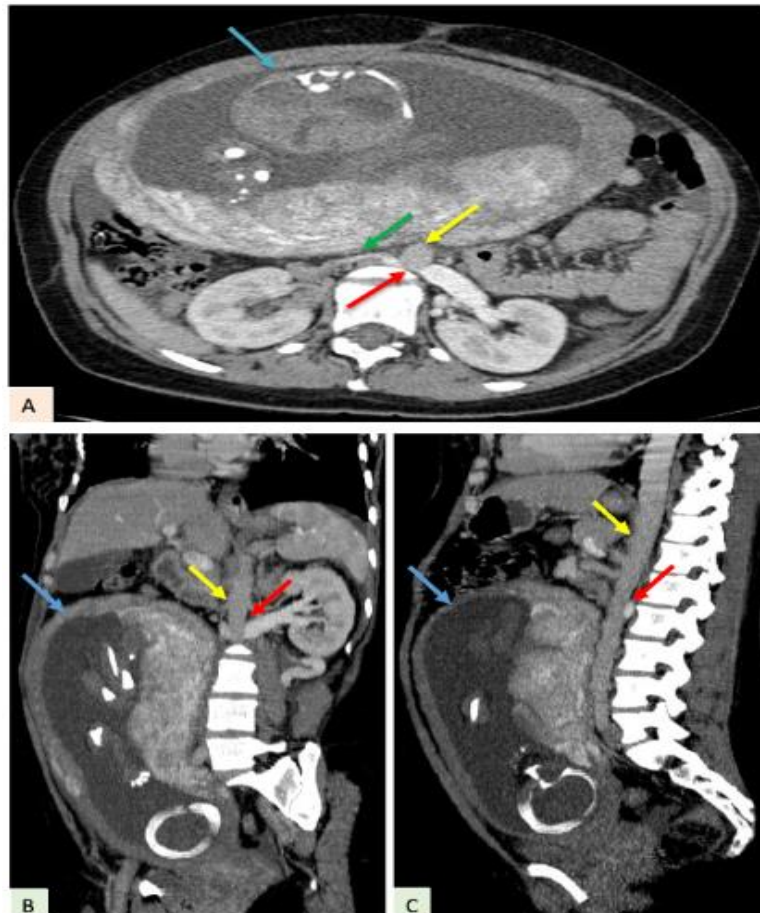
Axial (A) coronal oblique (B) and sagittal (C) sections of the abdominal-pelvic CT scan of our patient after injection of PDC (contrast medium), objectifying the passage of the left renal vein (red arrows) between the posterior aspect of the aorta (yellow arrows) and the anterior aspect of the vertebral body, which then drains into the inferior vena cava (green arrow) which is collapsed due to compression by the gravid uterus (blue arrows).
